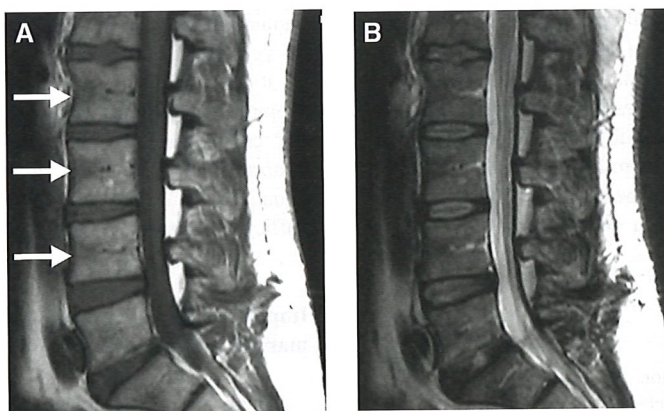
Normal marrow. (A) Sagittal T1- and (B) T2-weighted SE of the lumbar spine of a 44-year-old man show moderate decrease in signal intensity in the anterior aspect of the vertebral bodies (arrows). Note that the same pattern of more cellular red marrow distribution is present in all vertebral bodies.
